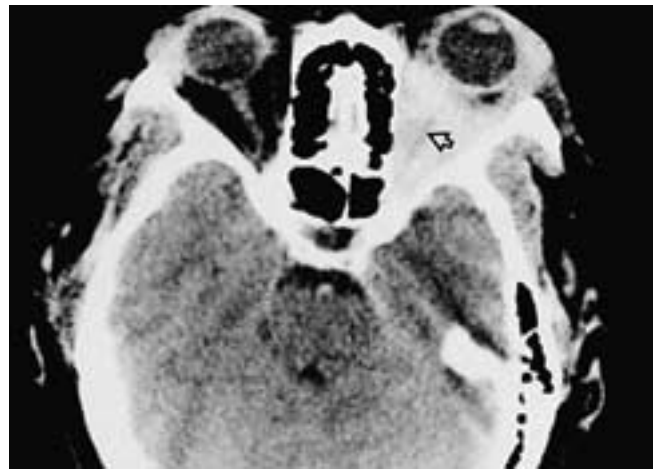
Pseudotumor. Axial CT scan shows diffuse infiltration of the entire retrobulbar space. The optic nerve appears as a lucent band (arrow) embedded within the lesion. (From Curtin HD. Pseudotumor. *Radiol Clin North Am* 1987;25:583.)
